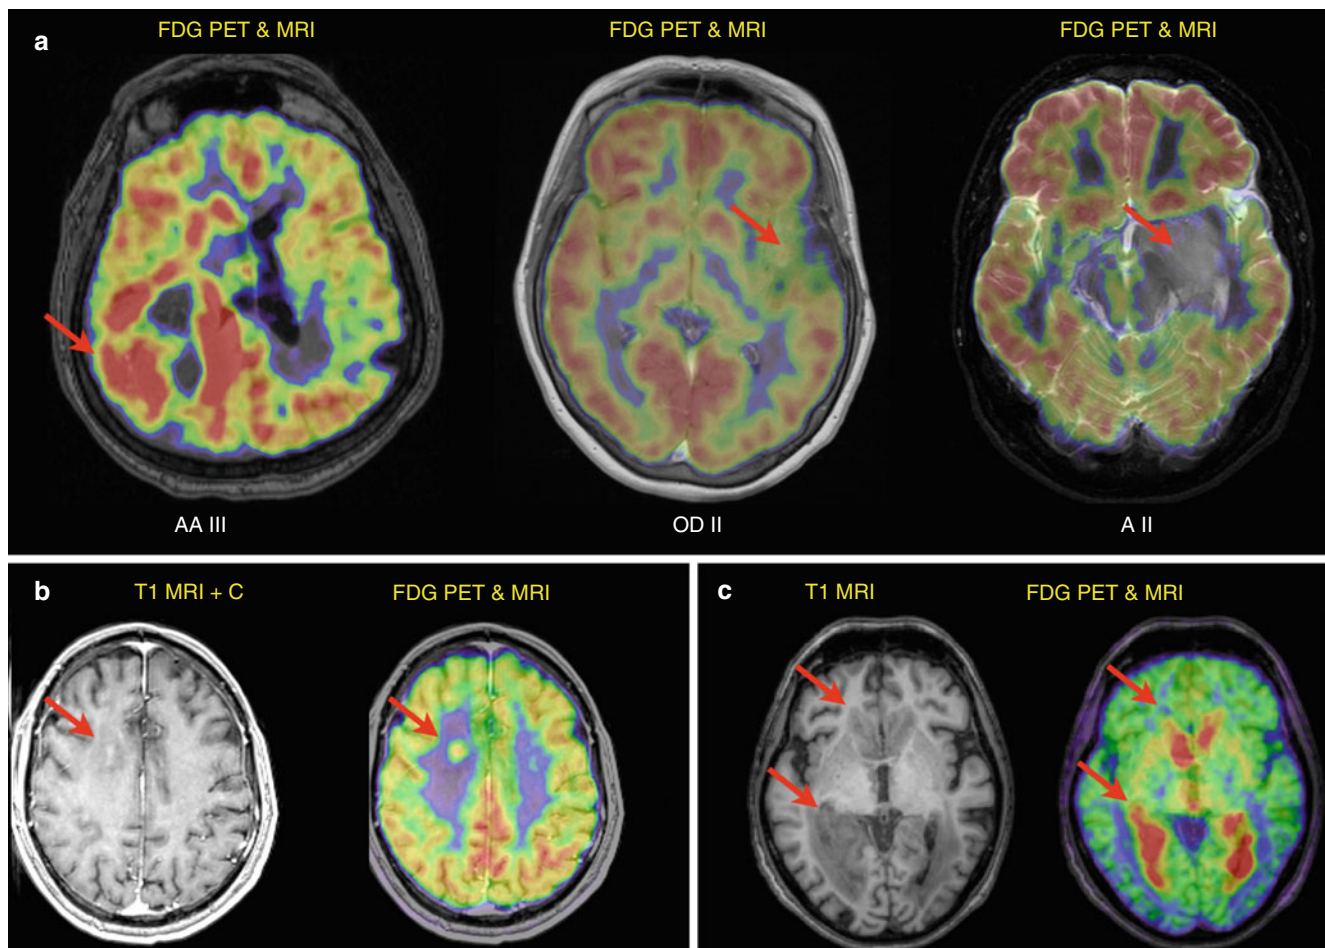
Co-registered FDG PET to MRI images showing typical examples of uptake in brain tumours. (a) *FDG uptake in high- and low-grade glioma.* From right to left: Anaplastic glioma (AA III) in the right parieto-occipito-temporal region with invasion of the central area and a cystic/necrotic area, oligodendroglioma (OD II) in the left insula and anterior temporal region and astrocytoma (A II) in the left insula and inferior temporal region. High-grade gliomas (III, IV) typically have uptake above healthy white matter, and low-grade gliomas (II) have uptake below healthy white matter. Oligodendroglioma II (*centre*) may deviate from this pattern with uptake larger than white matter. Note the relatively difficult tumour delineation in areas bordering to the high
